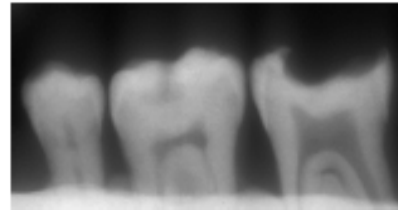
Digital radiograph, 0° after 24 hours
